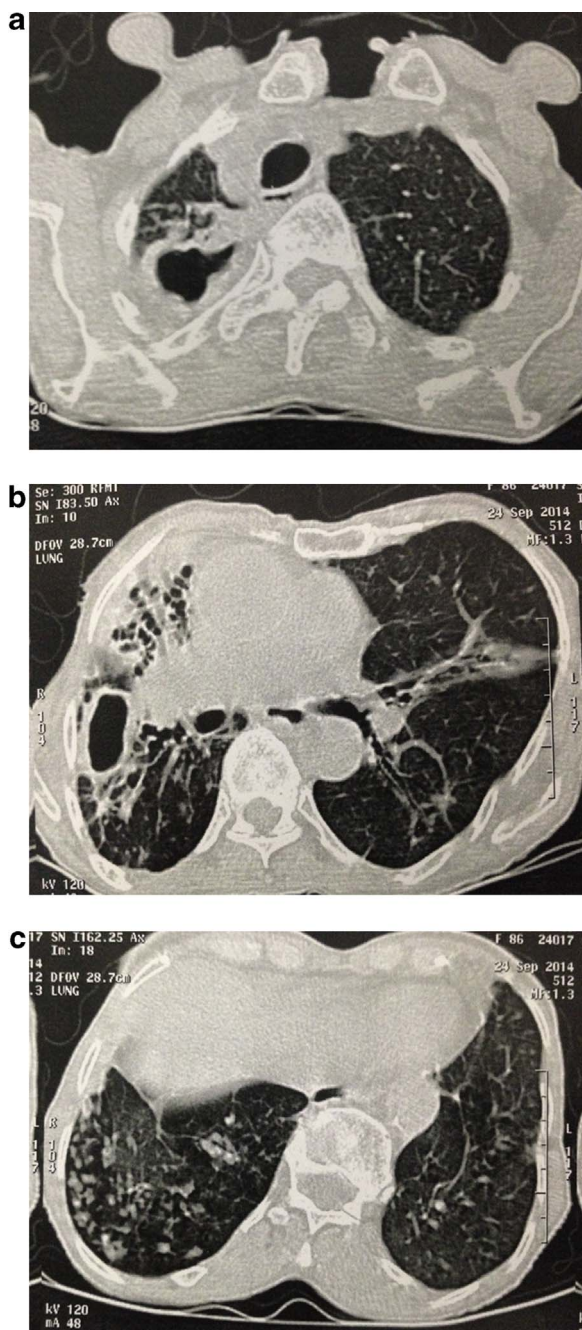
High-resolution computed tomography images from patient with *M. paraffinicum* pulmonary disease, showing (A) cavitory lesion in right upper lobe; (B) cavitory lesion in right lung and bilateral bronchiectasis; and (C) centrilobular nodules in right lower lobe.
